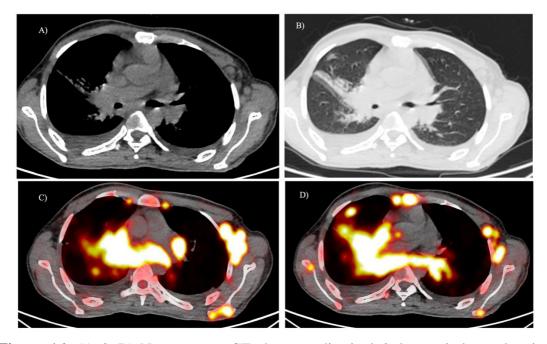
A) & B) Non-contrast CT chest, mediastinal & lung windows showing lymphomatous infiltration of the right lung with bilateral pleural effusion. C) & D) PET/CT images showing multiple FDG avid lesions in the mediastinum, lung and axilla and the sternum and scapula.
